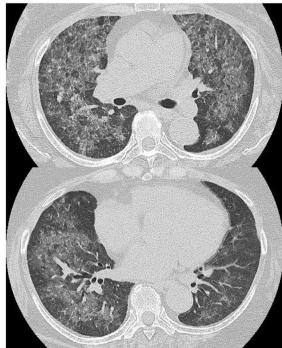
A chest roentgenogram (A) and computed tomography (B) one week before death, showing diffuse ground-glass attenuation bilaterally.
